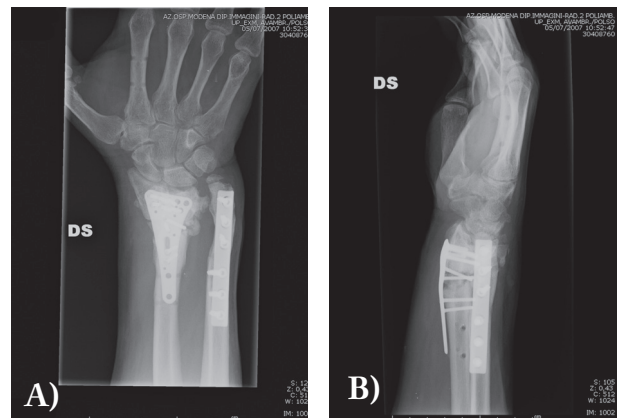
(Case 1): A) AP view X-ray 4 months post 2nd operation; B) LL view X-ray 4 months post 2nd operation
